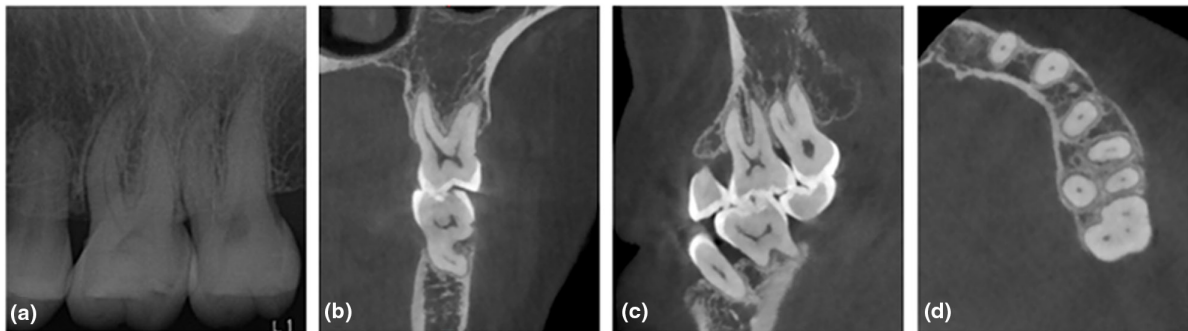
Intraoral examination and radiological examination of Teeth 16 and 26 before treatment. (A) Intraoral examination. (a, b) The right maxillary. (c, d) The left maxillary. (e, f) Probe on tooth 16. (B) Radiological examination of Tooth 16. (a) Apical radiograph taken 7 months before the first visit. (b) The apical radiograph on the first visit in December 2020. Three-dimensional reconstruction. (c–f) CBCT on the first visit. (d) Coronal scan. (e) Sagittal scan. (f) Axial scan. (C) Radiological examination of Tooth 26. (a) Apical radiograph. (b–d) CBCT. (b) Coronal scan. (c) Sagittal scan. (d) Axial scan.
